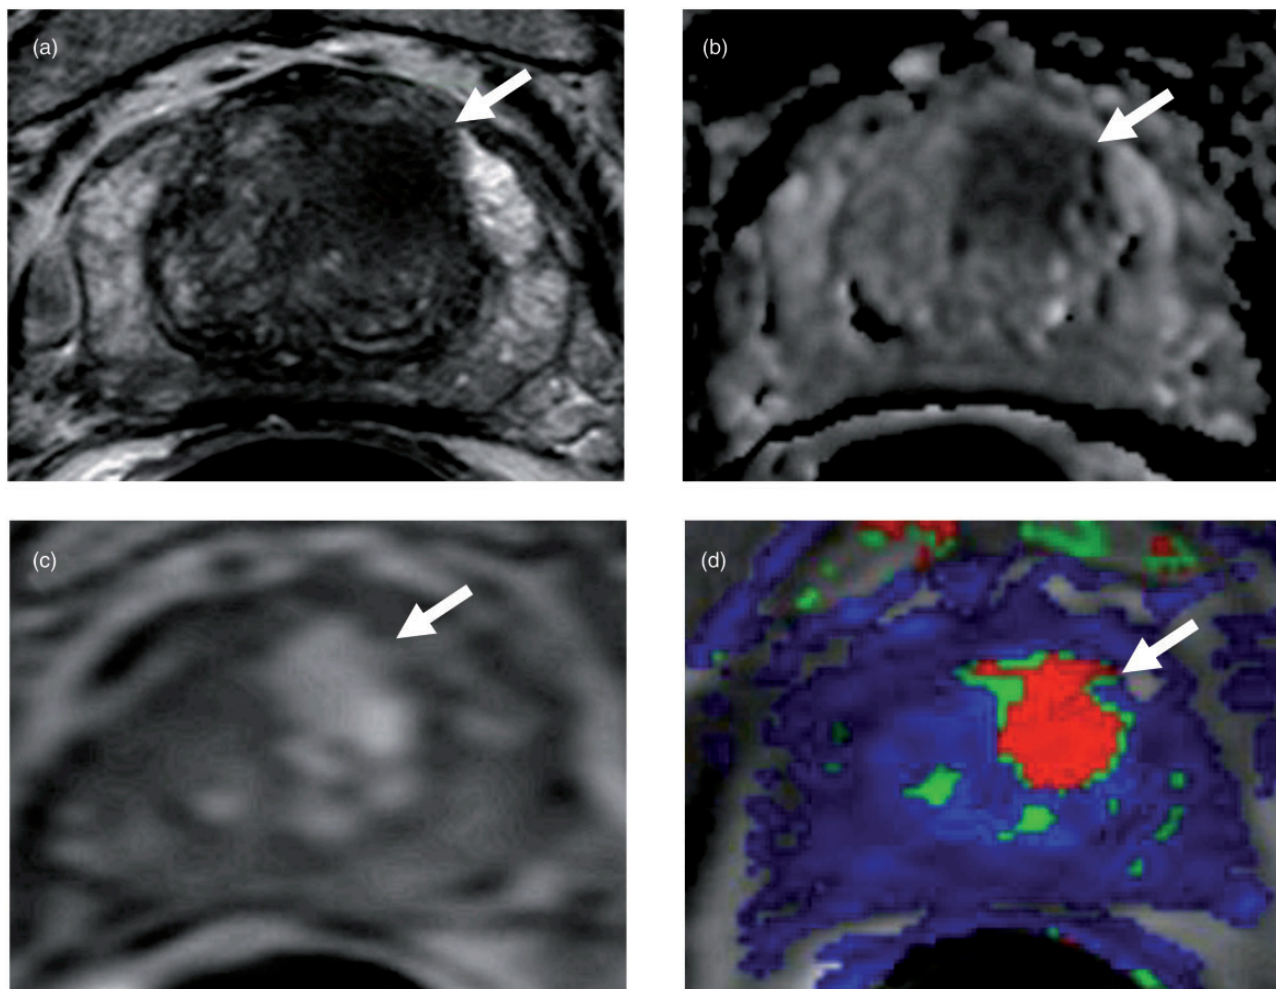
A 65-year-old man with a history of two prior negative TRUS-guided prostate biopsies. Axial T2W MRI shows a hypointense lesion in the left mid anterior transitional zone (arrow) (a). ADC maps of DW MRI (b), raw DCE-MRI (c), and ktrans (wash in) map of DCE-MRI (d) confirms this finding (arrows). TRUS/MRI fusion-guided biopsy revealed Gleason 3 + 4 prostate cancer within this left sided lesion
